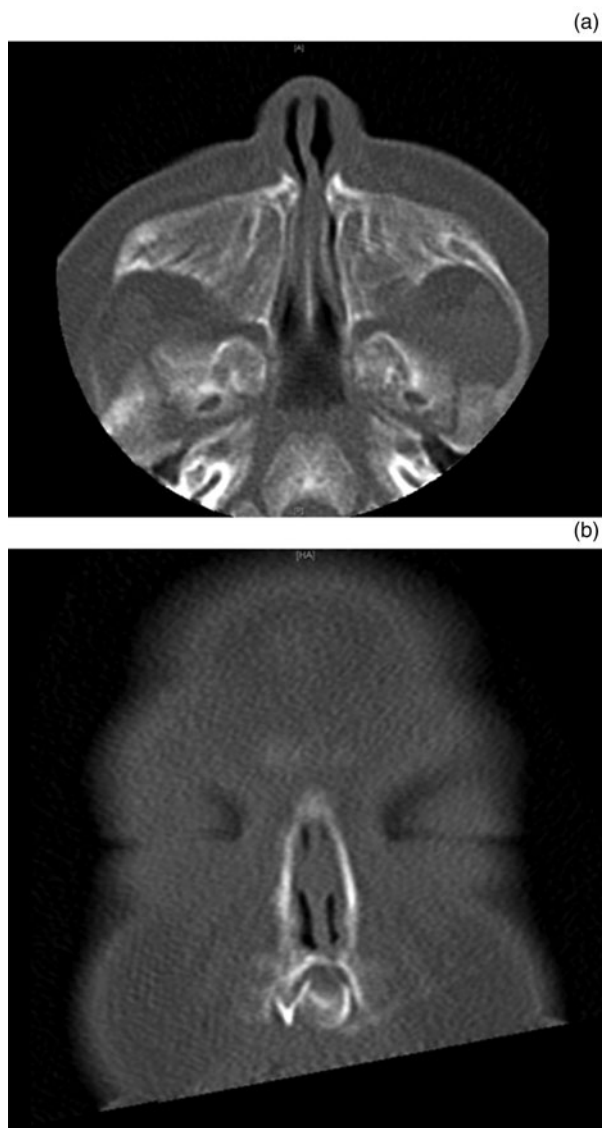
(a) Axial computed tomography (CT) scan demonstrating a narrowed pyriform aperture. (b) Coronal CT scan demonstrating a single maxillary incisor.
